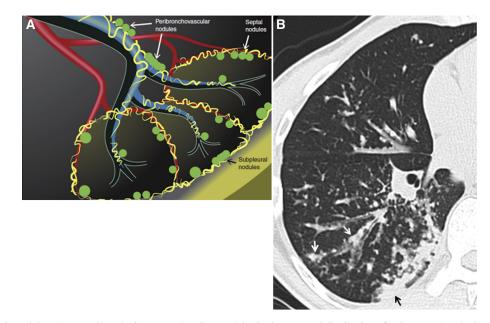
Perilymphatic nodules. (A) A perilymphatic pattern describes nodules in the expected distribution of pulmonary lymphatics: along pleural surfaces, interlobular septa, and the peribronchovascular interstitium. (B) Sarcoidosis. Computed tomography image, showing peribronchovascular (white arrows) and subpleural (black arrow) nodularity. This figure is available in colour online at http://carjonline.org/.
